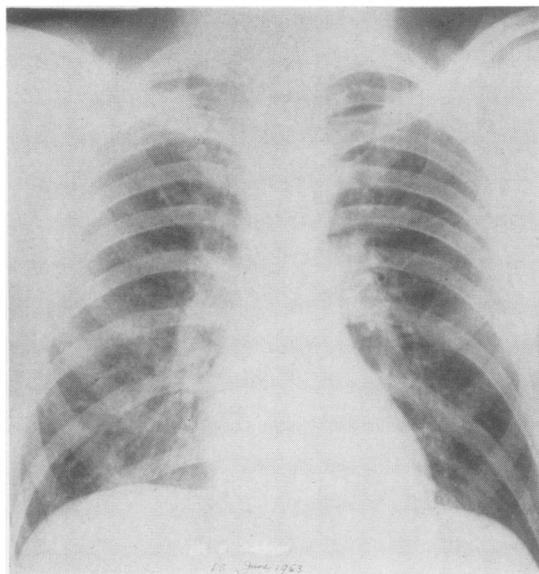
Chest radiograph taken during factory survey of June, 1953. Regarded as within normal limits.
